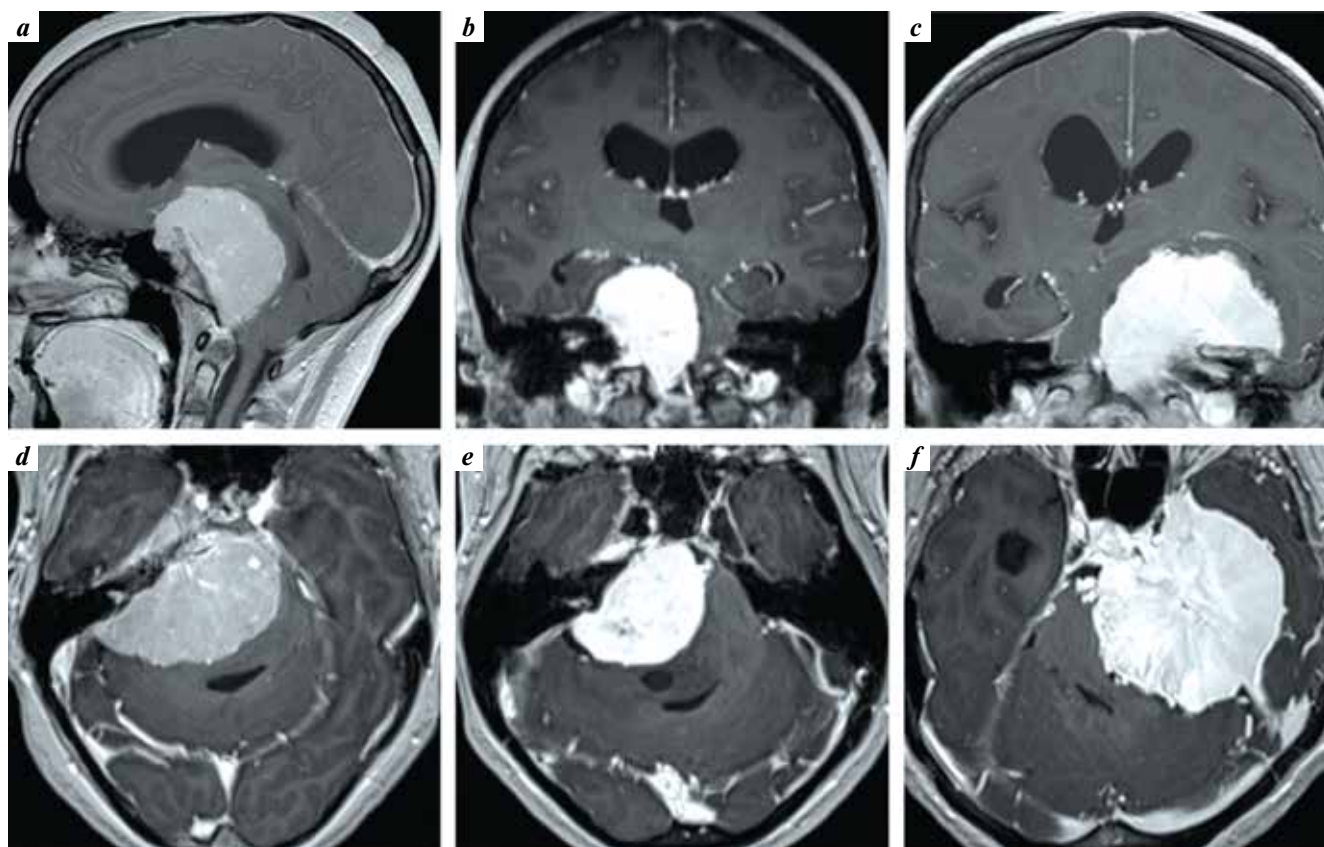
Examples of brain magnetic resonance images (contrast-enhanced T1-weighted) of patients with giant petroclival meningiomas (a–f): a, d – female patient, 31 years, Karnofsky performance scale (KPS) 80 %, admitted with complaints of headache, unsteady gait, hyperesthesia in the left half of the face, exotropia, difficulty swallowing solid food; b, e – female patient, 50 years, KPS 80 %, admitted with complaints of unsteady gait, exotropia, impaired hearing on the right, and weakness in the right half of the face (House–Brackmann score 2); c, f – female patient, 64 years, KPS 70 %, admitted with complaints of unsteady gait, weakness in all limbs (4 points) and in the left half of the face (House–Brackmann score 3), absence of hearing on the left, and pain in the right half of the face
